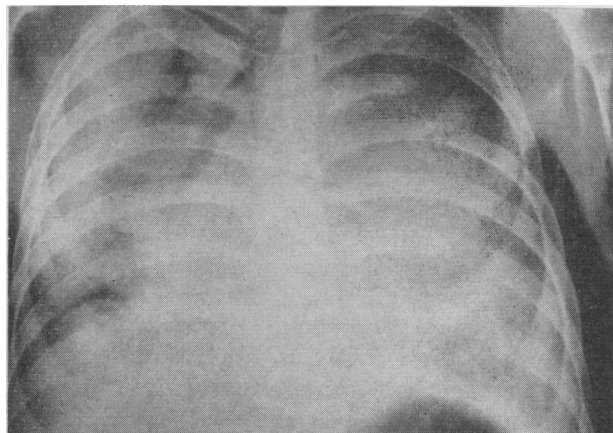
Chest radiograph of recipient seven days post transplantation.
